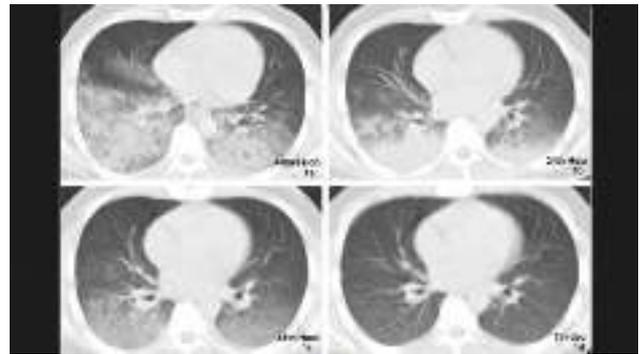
CT of the first patient on admission (a); at 24th hour (b); at 48th hour (c) and control at 7th day (d)
